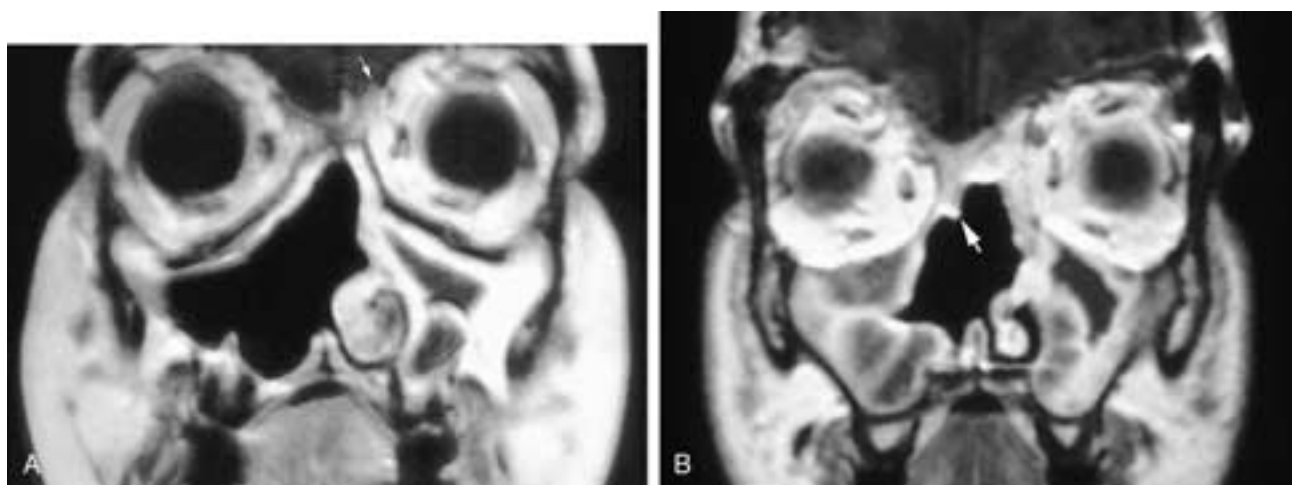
Coronal T1-weighted, contrast-enhanced MR images on two different patients who have had craniofacial procedures. In (A) the mucosa lining the postoperative nasal cavity and the right maxillectomy cavity is smooth and normal. There is a sinusitis with entrapped secretions in the left antrum. The graft in the floor of the anterior cranial fossa enhances minimally, and if one is not careful, one may overlook the extent of the removed bone, especially in the skull base. A focal area of nodularity is seen (arrow) along the intracranial margin near the left attachment of the graft to the bone. This remained stable in appearance over several postoperative years. In this patient, this was a postoperative variant, and it points out the value of obtaining baseline postoperative images. In (B) the intracranial margin is smooth, but there is a focal nodule along the right sinonasal margin (arrow). Although this area is easily accessible to clinical observation, it was also present on the baseline scan and remained unchanged. There is also bilateral antral inflammatory disease.
